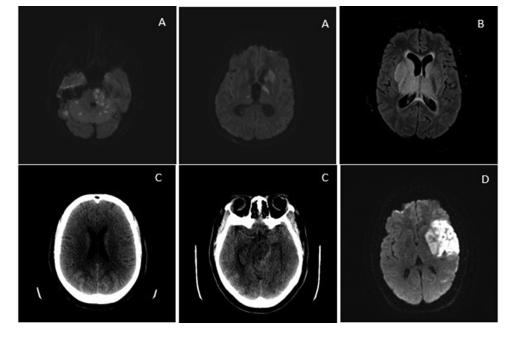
A. Patient 1: Ischemic stroke, DWI sequence showing embolic stroke pattern in the anterior and posterior circulations. B. Patient 12: Venous infractions, FLAIR sequence of MRI brain showing bilateral hyper intensities. C. Patient 16 SAH, CT HEAD SHOWING SAH in the left ambient cistern, quadrigeninal plate cistern and bilateral parieto-occipital lobes. D. Patient 6: Large vessel ischemic infract, DWI sequence with diffusion restriction in the left MCA territory.
